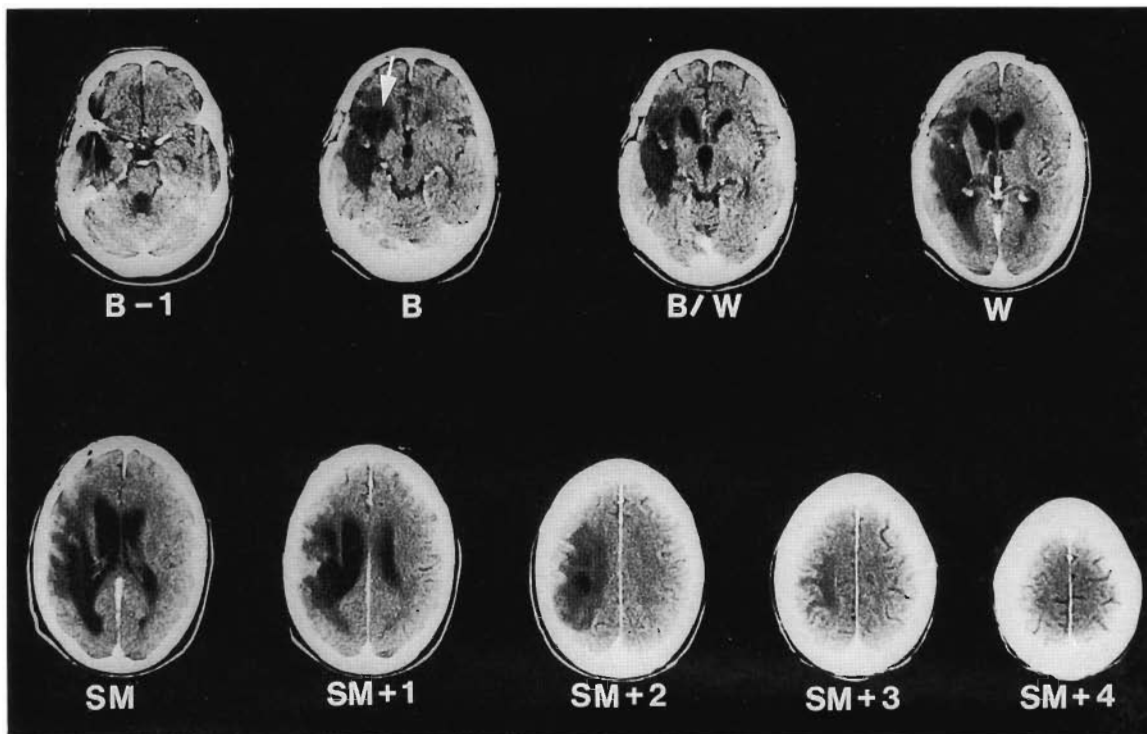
CT scan for patient SJ, performed 3 years postsurgery for an aneurysm. SJ had no spontaneous speech 3 years postonset. This CT scan shows extensive lesion in the medial ScF area on slice B and slice B/W. In fact, the medial ScF lesion is so deep on slice B that it touches the frontal horn (arrow). The extent of lesion rating for the medial ScF on slice B was 4.9 (almost completely solid lesion), and the rating for the medial ScF area on slice B/W was 3.5 (patchy—more than half of the area has lesion); the mean extent-of-lesion rating for the medial ScF area was 4.2. The extent-of-lesion rating for the $M\frac{1}{3}$ PVWM area on slice SM was 3 (lesion in half of the area). The total extent-of-lesion rating for these two subcortical areas on CT scan was 7.2—i.e., a rating compatible with no recovery of meaningful spontaneous speech. (CT scan slice thickness was 10 mm, performed at 7-mm intervals.)
